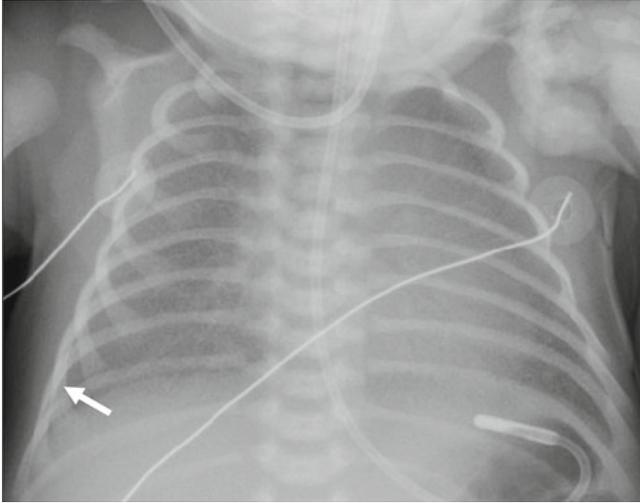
Transient tachypnea of the newborn. Radiograph shows diffuse and bilateral prominent interstitial markings, and a small right pleural effusion (*arrow*). Note hyperinflation of the lungs
